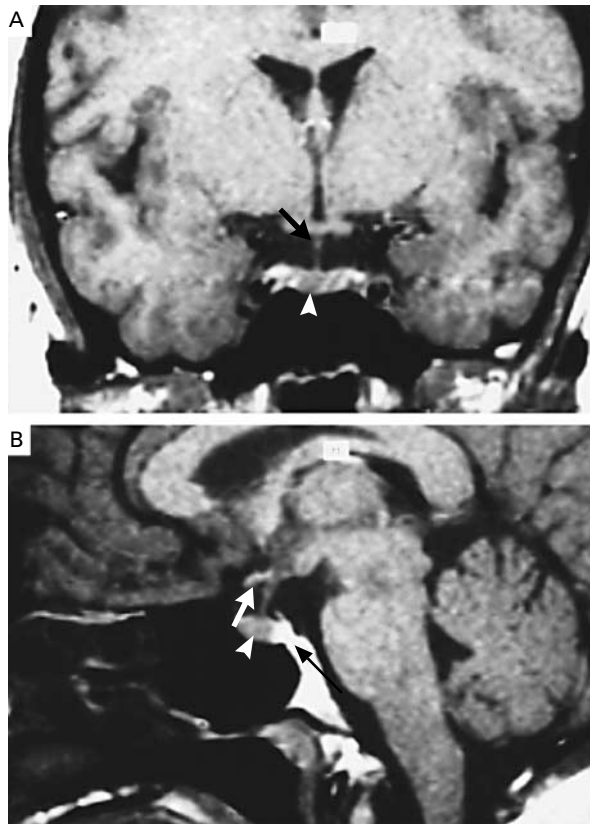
MRI Scans of the Hypothalamic–Pituitary Region in a Normal Subject (Panels A and B) and Two Patients with Central Diabetes Insipidus (Panels C, D, E, and F).
